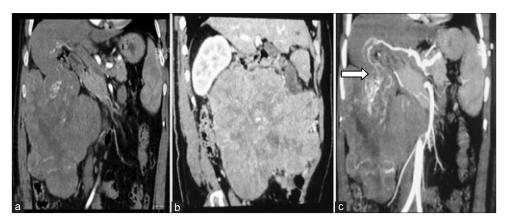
(a) Coronal; and (b) sagittal; images of abdominal CT scan showing the continuity of the mass with the inferior surface of the liver. (c) Coronal; image demonstrates the enlarged posterior branch of right hepatic artery; supplying the mass (arrow; feeding artery sign) which confirms the organ of origin
